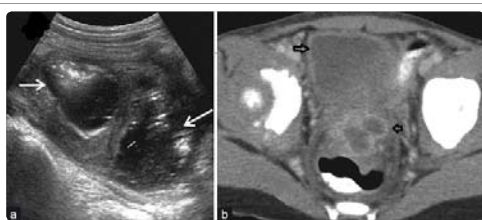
Ultra-sonography (A) and C.T (B) scan showing pelvic collection.
